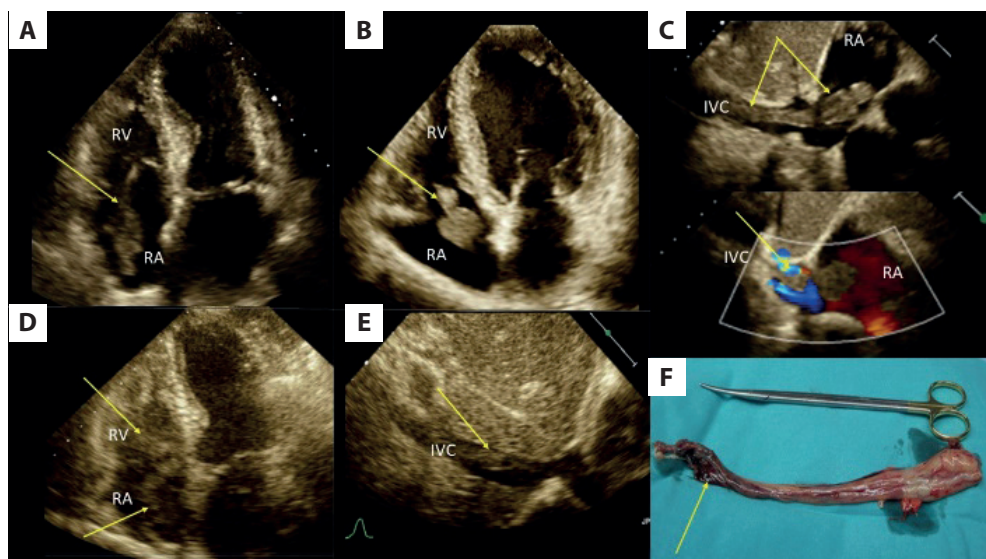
Two-dimensional transthoracic echocardiography in patients with mobile pathological masses found in the right heart. A. Mobile thrombus in the right atrium (the arrow) in a patient with a pulmonary embolism; four-chamber view. B. Mobile pathological mass in the right atrium (the arrow) in a patient with renal cell carcinoma; four-chamber view. C. The inferior vena cava filled with pathological mass (renal cell carcinoma) entering the right atrium (the arrows, top panel); venous flow limitation visible in the color Doppler assessment (the arrow, bottom panel); subcostal view. D. Mobile pathological mass in the right heart (the arrows) in a patient with endometrial stromal sarcoma; four-chamber view. E. Additional mass (stromal sarcoma) in the inferior vena cava (the arrow); subcostal view. F. Stromal sarcoma surgically removed; part of a tumor visible in the right heart on echocardiography (the arrow)
